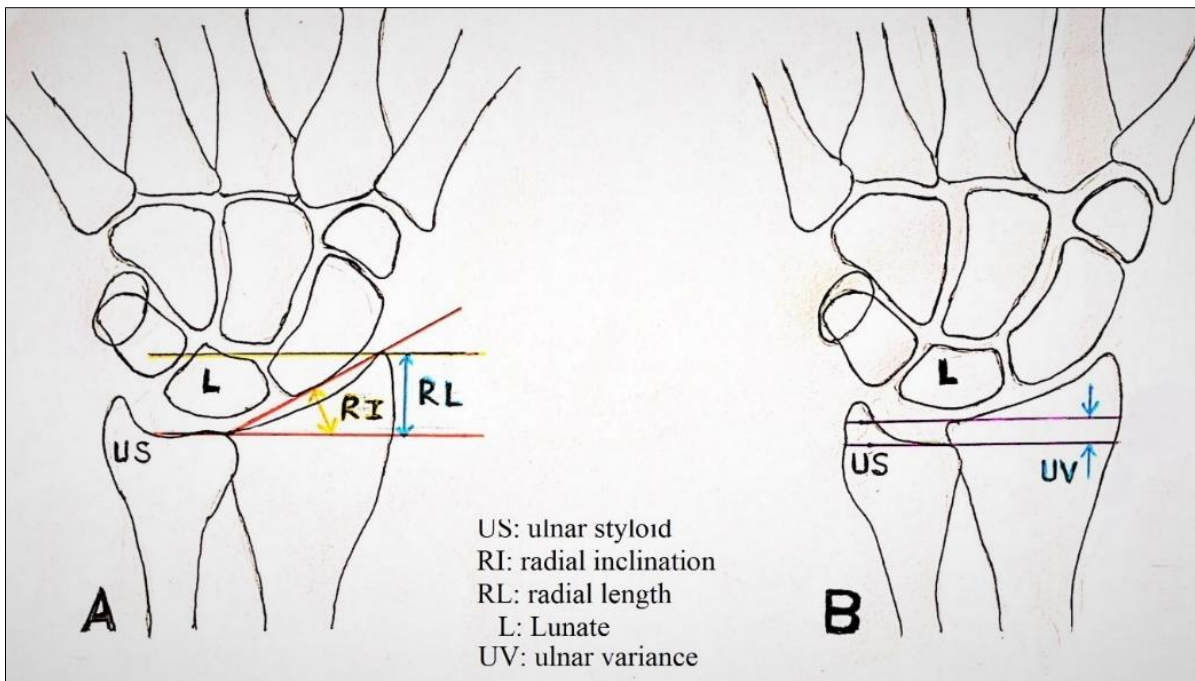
Radiographic parameters distal radius
